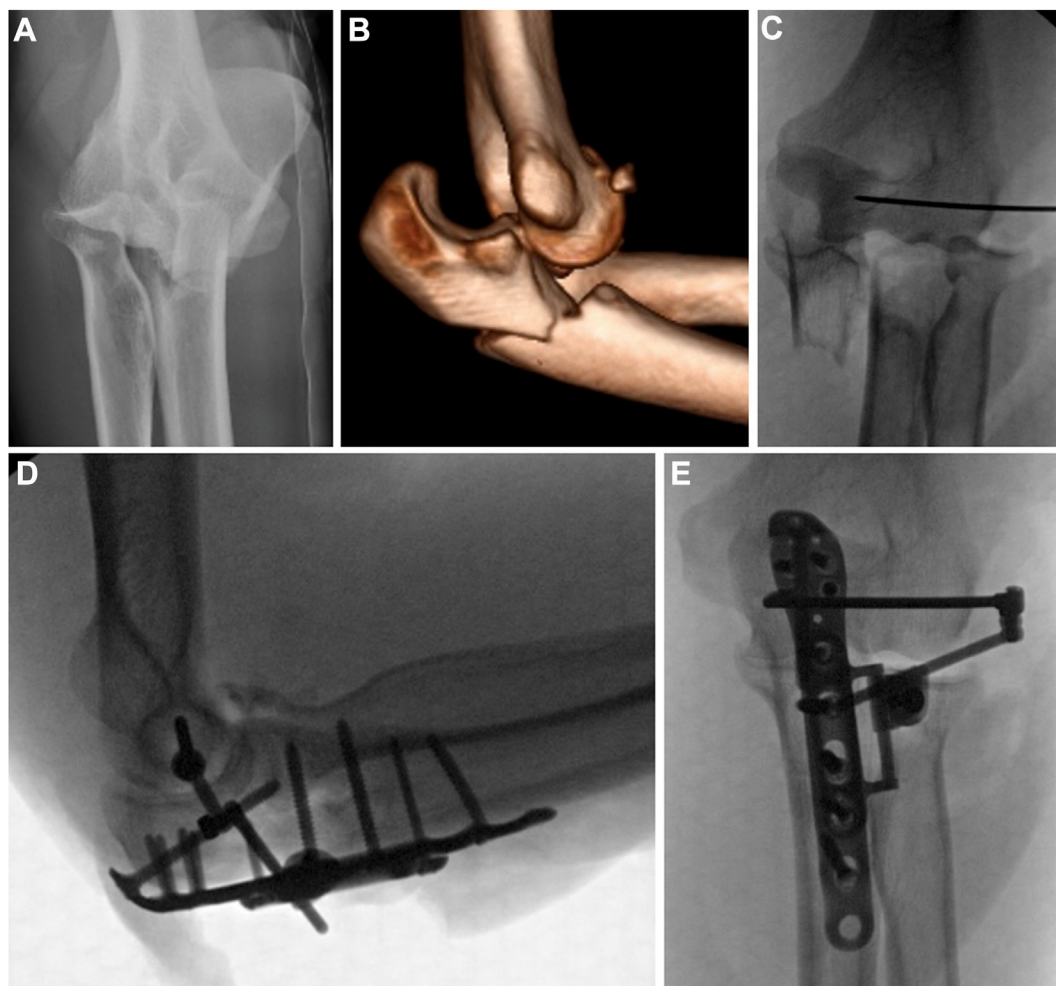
(A) Radiography and (B) computed tomography demonstrating Monteggia fracture dislocation. (C) Intraoperative fluoroscopy of wire placement across the ulnohumeral axis of rotation prior to fracture fixation, and (D and E) final fixation construct with the internal joint stabilizer placed on top of the proximal ulna plate.
